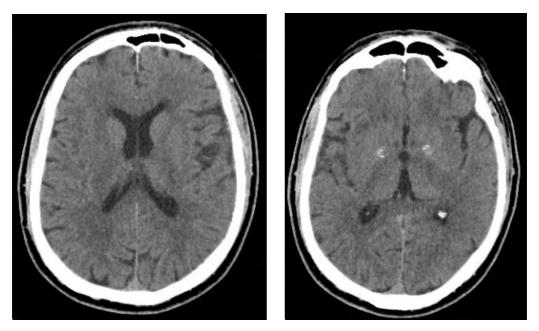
Skull Computed Tomography
